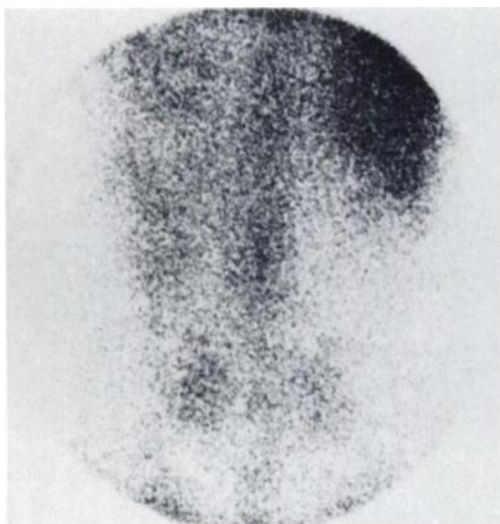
No renal activity demonstrated on gallium-67 citrate scintigraphy. Five of 12 patients diagnosed with noninfectious interstitial nephritis showed no accumulation of Ga-67 in kidney area.
